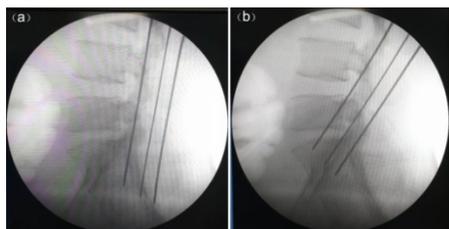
The establishment of accurate location. (a): The anteroposterior X-ray image was obtained for confirming the spinous process was located in the midline and both ends of targeted spinal levels were on the same line. Then a regular triangle can be seen as shown. (b): The lateral X-ray image was obtained for confirming the bilateral superior articular processes were overlapped, just as shown.
